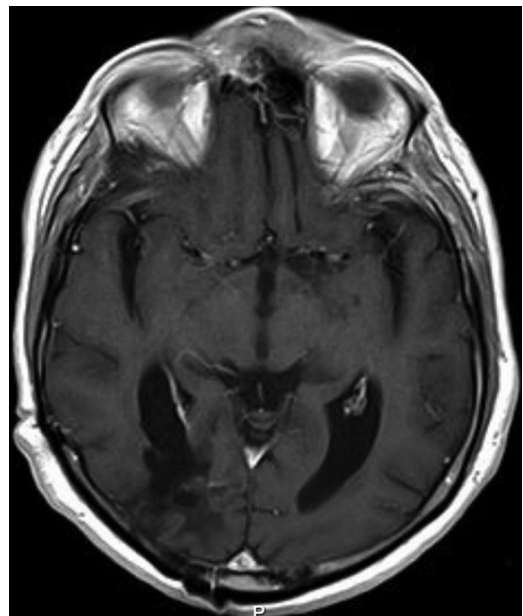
Gadolinium-enhanced T1-weighted MRI performed 12 months after metastasis removal, showing no traces of secondary disease at the site.
